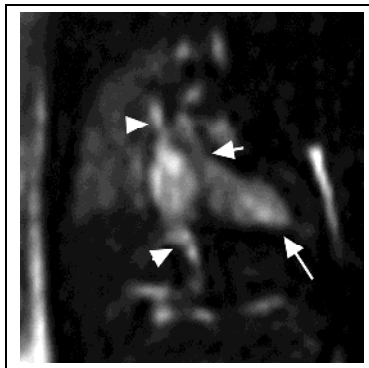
Coronal MRI of normal fetal heart at 24 weeks' gestation shows SVC and IVC (arrowheads) draining into right atrium, cardiac apex (long arrow), and LVOT (short arrow)
